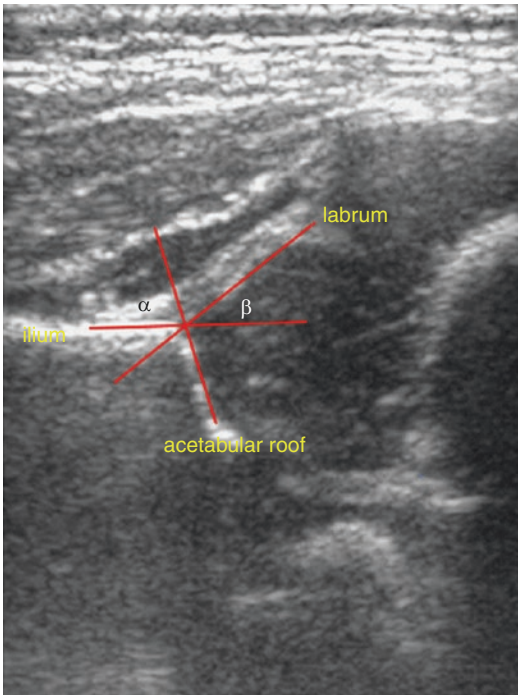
Coronal view of hip ultrasound showing the normal positioning of the femoral head in acetabulum and the normal alpha angle. The beta angle also shown
